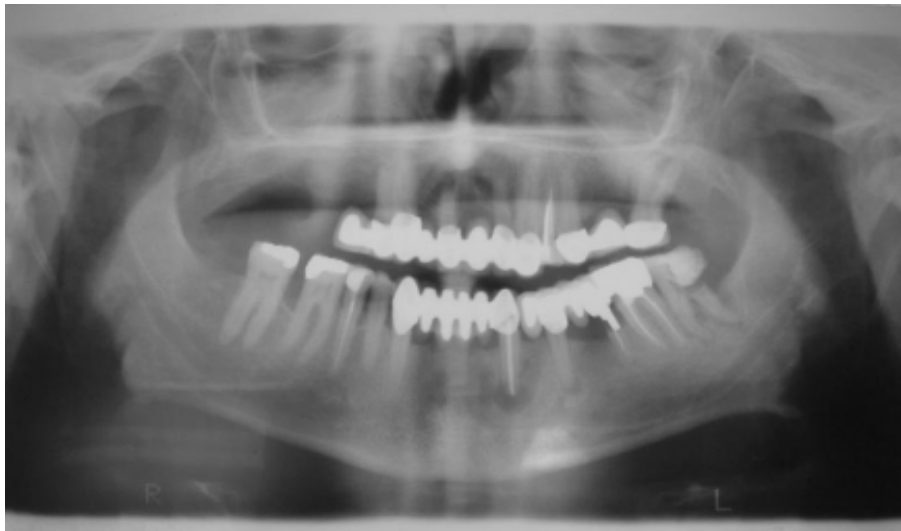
Panoramic radiograph of patient showing the elongated styloid process.
